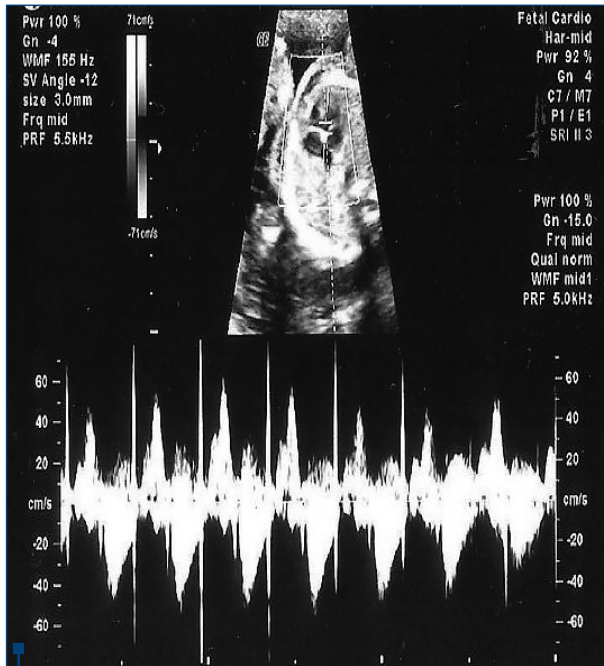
Doppler echocardiogram signals of aperture and closure of semilunar aortic valves when measuring Mod-MPI
